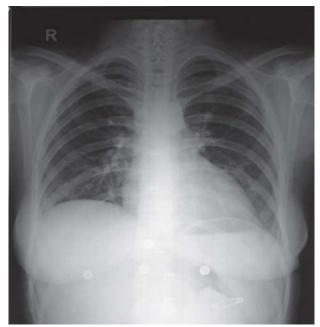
Chest radiograph (PA view) complete resolution of pneumatoceles after treatment.
